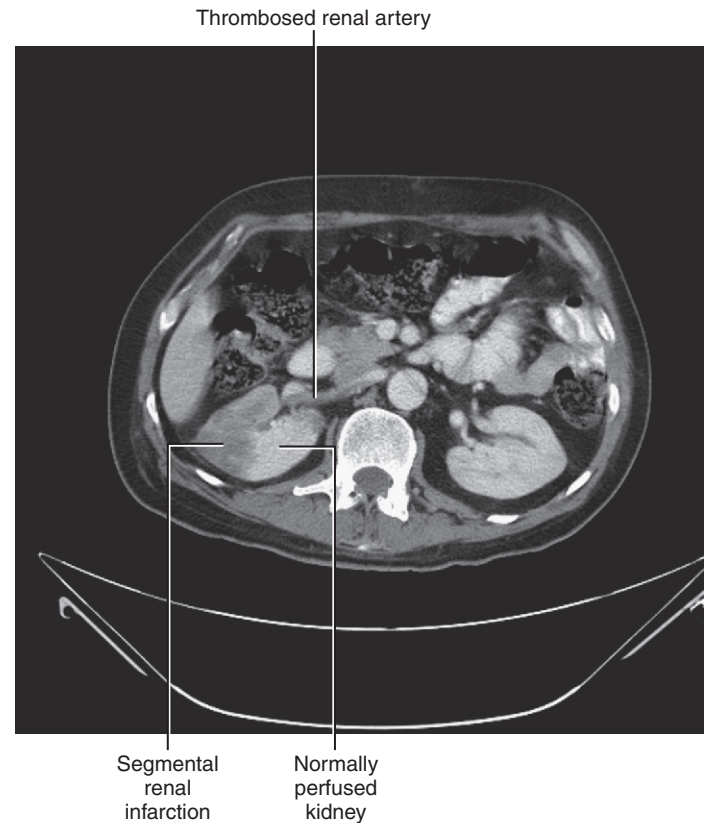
Contrast enhanced CT scan, transverse section, showing segmental renal infarction from renal artery thrombosis. (Image courtesy of Vikram Dogra, MD.)
